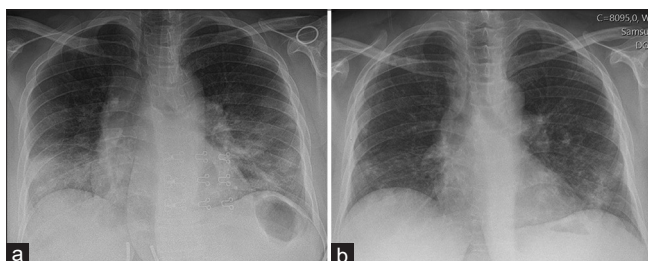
A 53-year-old female coronavirus disease 2019 patient presenting with fever and dry cough for 4 days. (a) Initial chest radiography reveals bilateral extensive peripheral consolidation in the middle and lower zones. (b) 2-week later, partial regression was noted in a follow-up chest radiography
